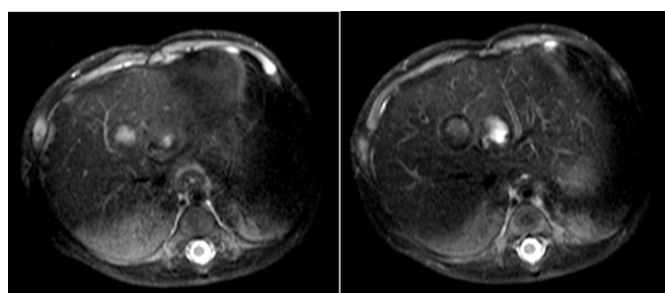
MRI showing two nodules in segments IV and VIII with 14 and 12 mm, respectively, hypointense on T1- and hyperintense on T2-weighted images, with filling-in in the arteriovenous phase.
